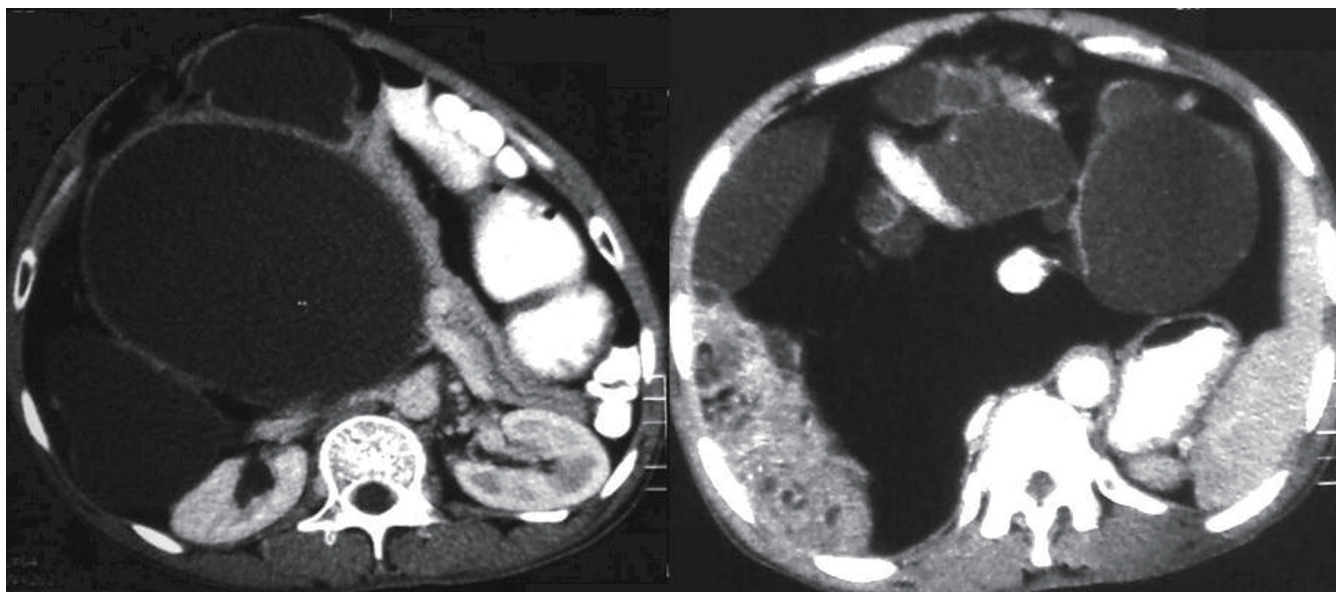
The contrast enhanced CT scan demonstrates a well circumscribed lobulated, multicystic lesion involving the head of pancreas. The cysts have thick walls with fine wall calcifications and mildly different levels of densities within the cyst cavities. Diffuse proliferation of fat is demonstrated around the cysts displacing small bowel loops
